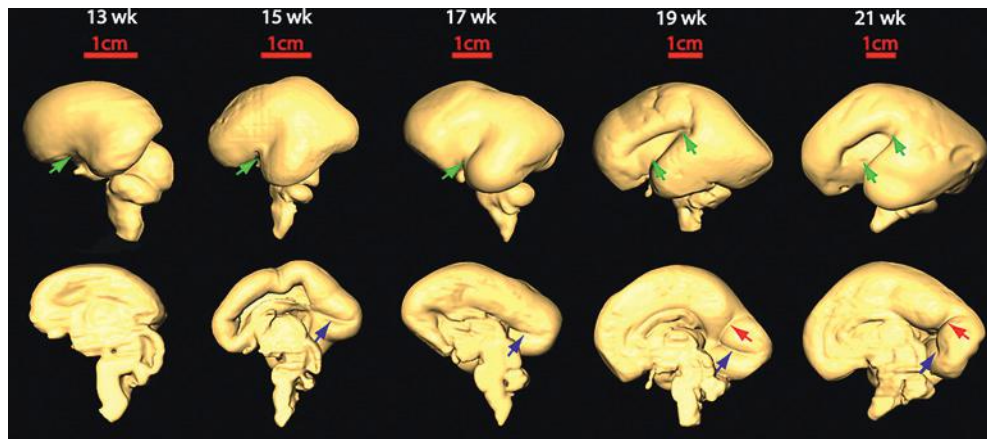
Three-dimensional reconstruction of the lateral (*top row*) and medial (*bottom row*) surface of 13- to 21-week fetal brains to reveal the development of the sylvian fissure (*green arrows*), the calcarine fissure (*blue arrows*), and the parieto-occipital sulcus (*red arrows*). (From Huang H, Xue R, Zhang J, et al: Anatomical characterization of human fetal brain development with diffusion tensor magnetic resonance imaging. *J Neurosci* 29(13):4263–4273, 2009.)
